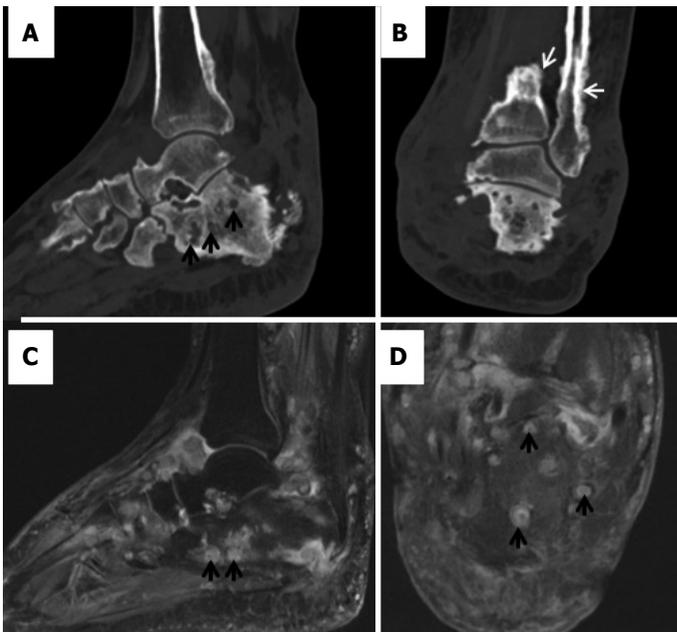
CT and MRI of ankle of the patient with eumycetoma in figure 5. (A, B) Sagittal and coronal reformats of CT of ankle show multiple osteolytic areas (black arrows) in calcaneum with periosteal reaction at lower end of tibia and fibula (white arrows) with soft tissue involvement, respectively. (C, D) Sagittal and coronal STIR MRI images show multiple lesions in calcaneum and soft tissues with dot in circle sign (arrows).
